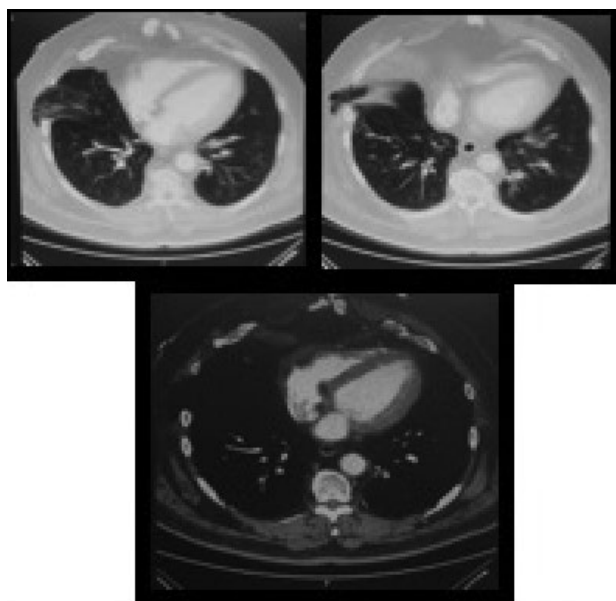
Axial CT views of middle lobe hernia.
